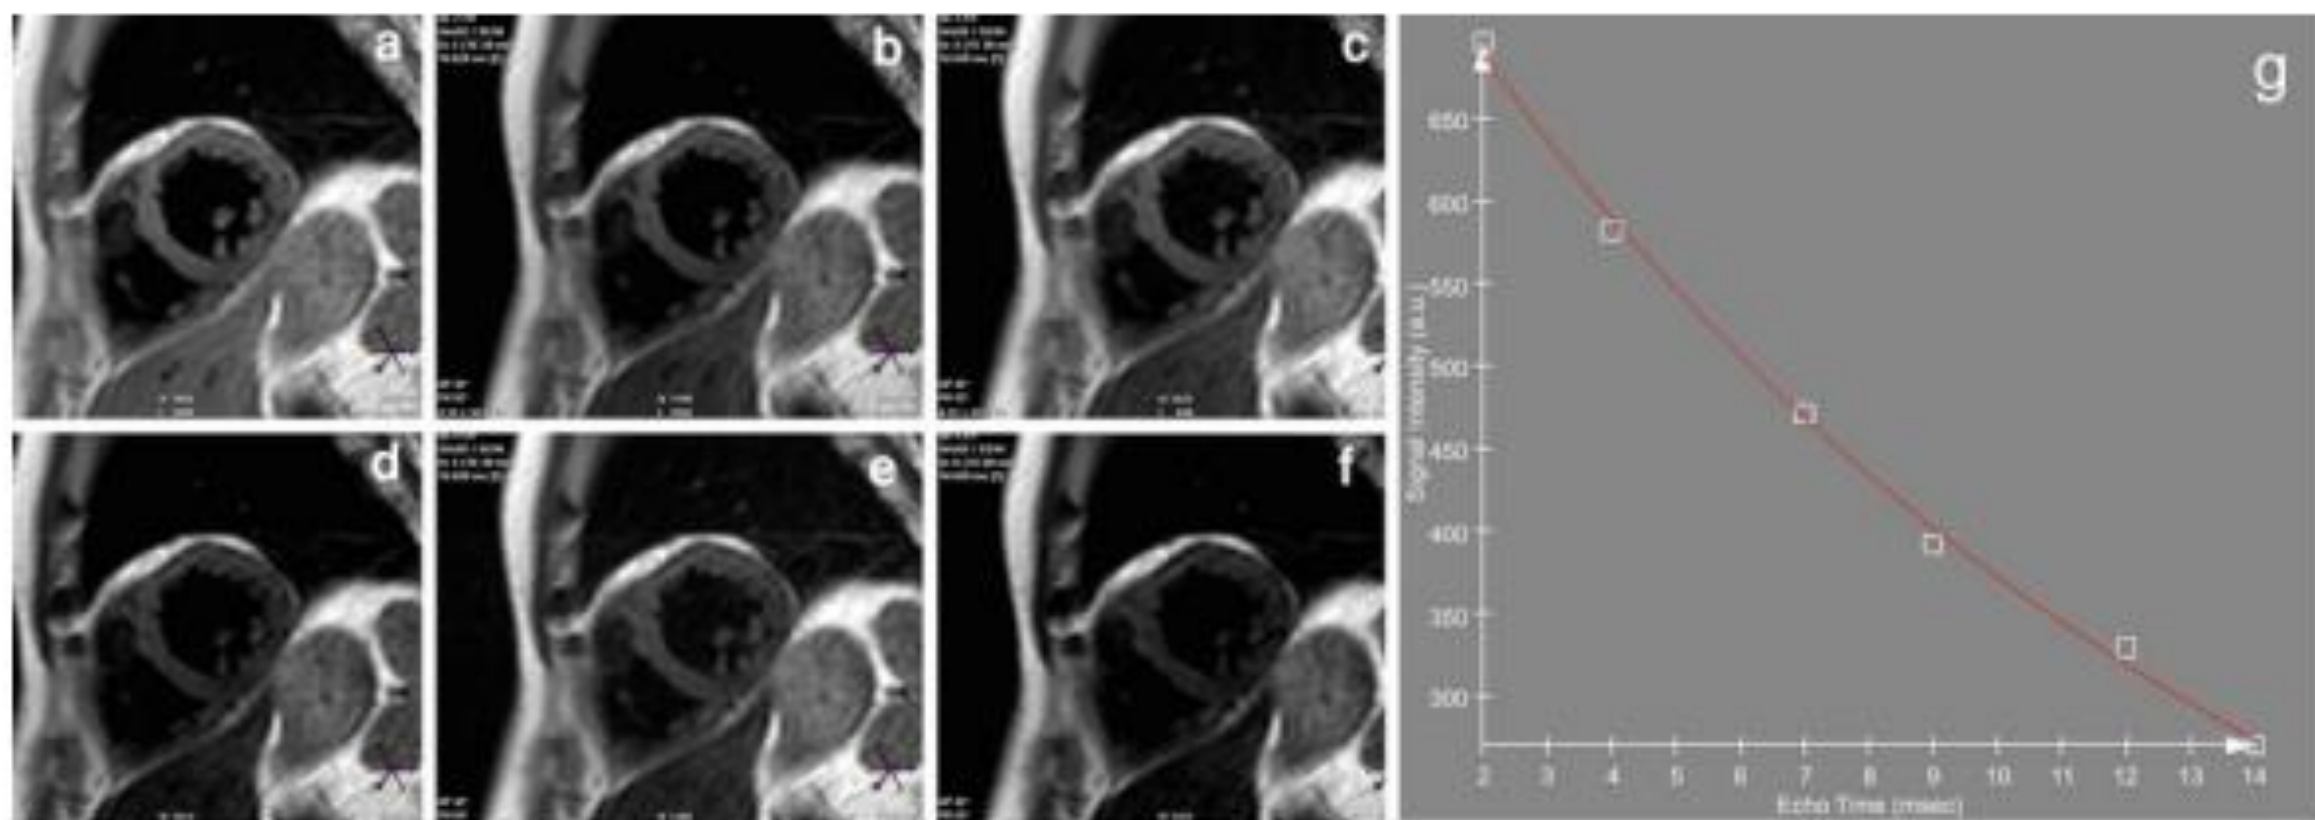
Hereditary hemochromatosis in a 56-year-old man. T2* imaging using GRASE MRI with 6 echoes (a–f), and corresponding T2* map (g). The myocardial T2* was 13 ms
